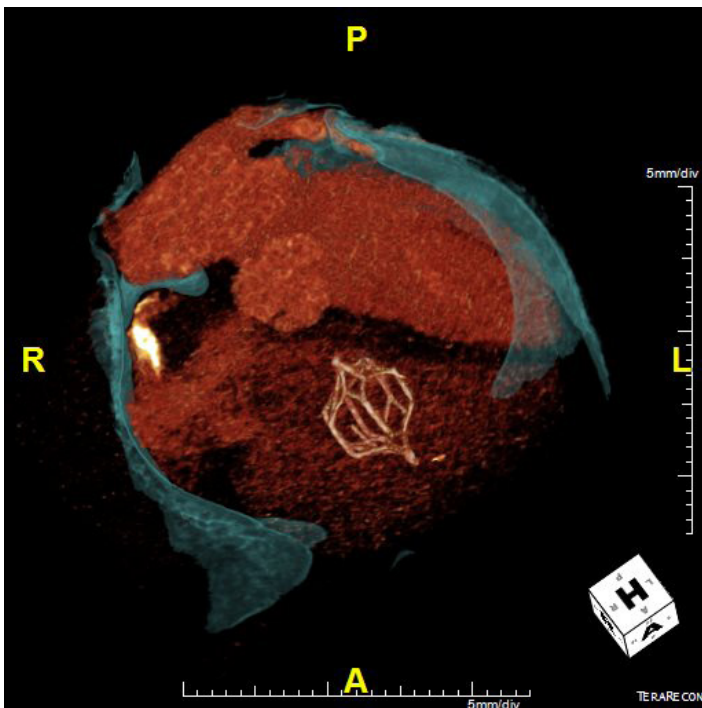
Computed tomography reconstruction displaying inferior vena cava filter lodged in right ventricle
